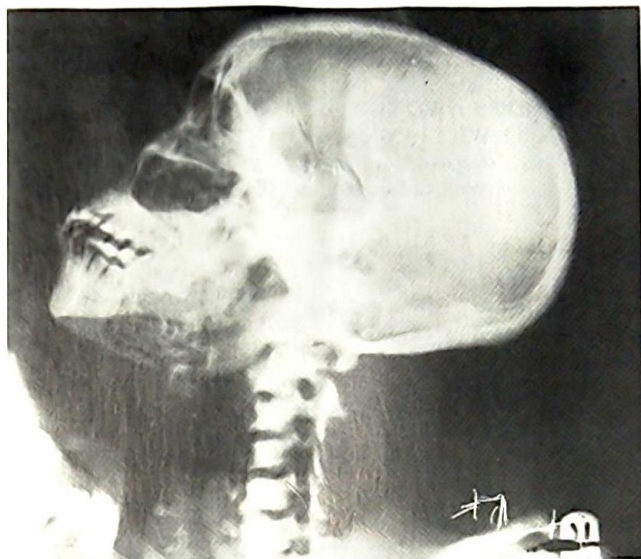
X-ray of patient's skull — showing chronic osteomyelitis of the left mandible. A sequestrum is present. Note the sclerotic base of skull and the vertebral bodies.
